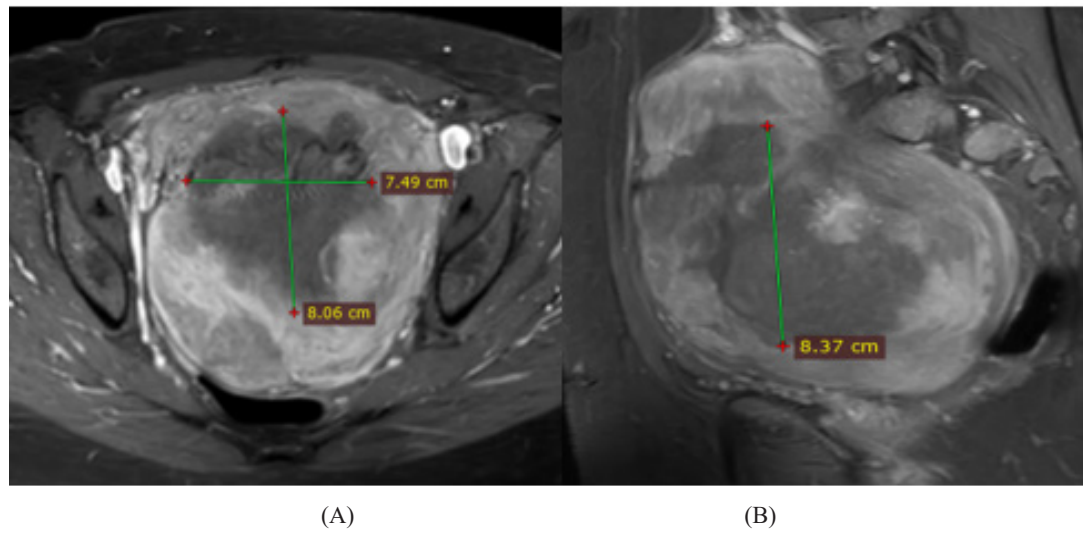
Post MR-HIFU for patient in figure 3. Axial (A) & Sagittal (B) post-contrast T1 MRI images revealed areas of non-enhancement within the former myoma denoting well ablation. Volume of ablated areas after HIFU = 265 cc, calculated NPV = 79%
